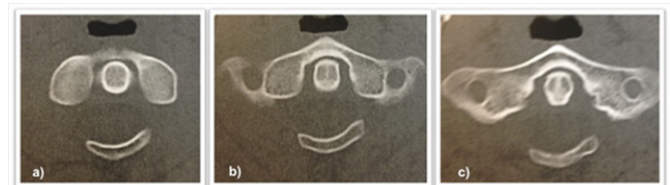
CT-scan (axial) showing a segmental aplasia of both hemiarches of the atlas.
